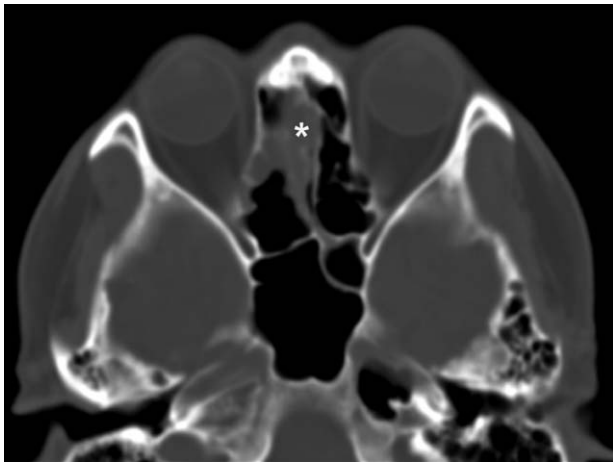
CT scan revealed a soft tissue mass with increased density in the right ethmoid sinus (A, as showed by the asterisk). CT=computed tomography.
